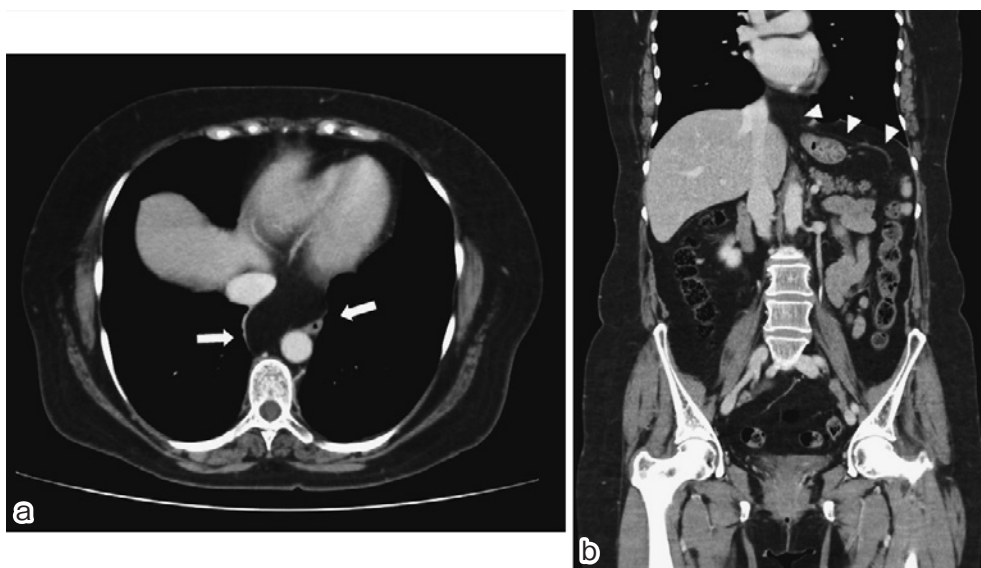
a: CT revealed an encapsulated retrocardiac low-density mass (arrows). b: Coronal CT revealed gastroepiploic vessels flowing into the fatty tissue of the posterior mediastinum (arrowhead).
